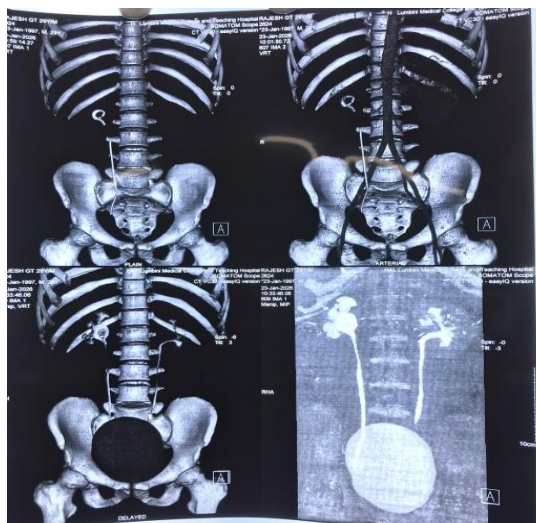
CT IVU shows small right kidney with moderate hydronephrosis, retained long-standing DJ stent with fragmentation.
